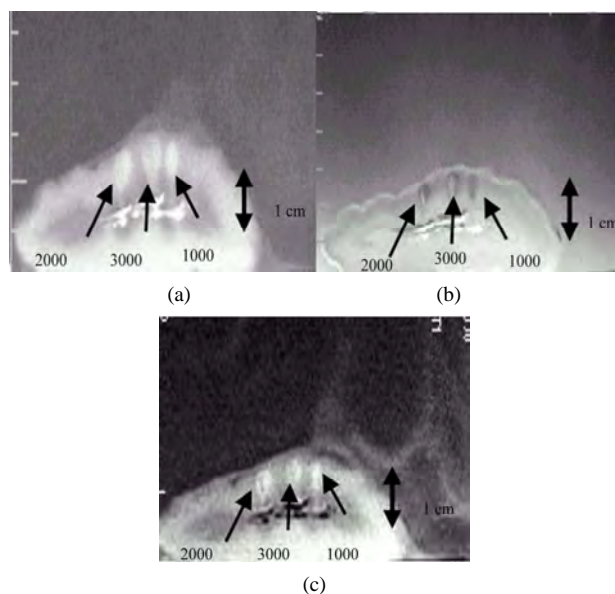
MR images (in a plane parallel to the beam) of 3 lesions in kidney *in vitro* using. (a) T1-weighted FSE; (b) T2-weighted FSE; (c) T1-weighted FSPGR. With intensities above 2000 W/cm² the lesions exhibit boiling activity. The discrimination between boiling and thermal lesion is best monitored using T2-W FSE.
